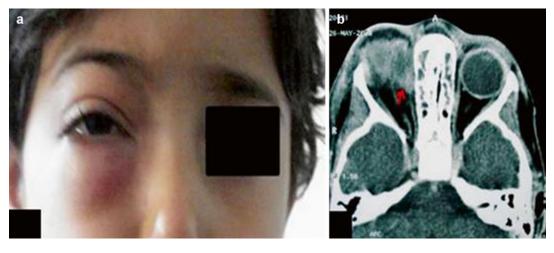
(a) Photograph of an 8-year-old girl shows palpebral swelling with erythema and mild proptosis. (b) Axial CT scan shows subperiosteal abscess (type 3 orbital
